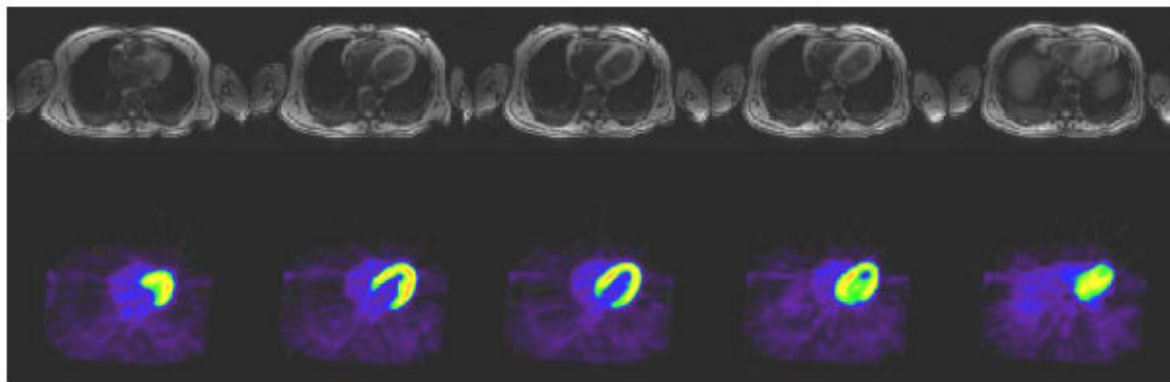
Coupes IRM transverses (en haut) recalées à des images TEP 18F-FDG (en bas) en télédiastole pour le cas E1.
